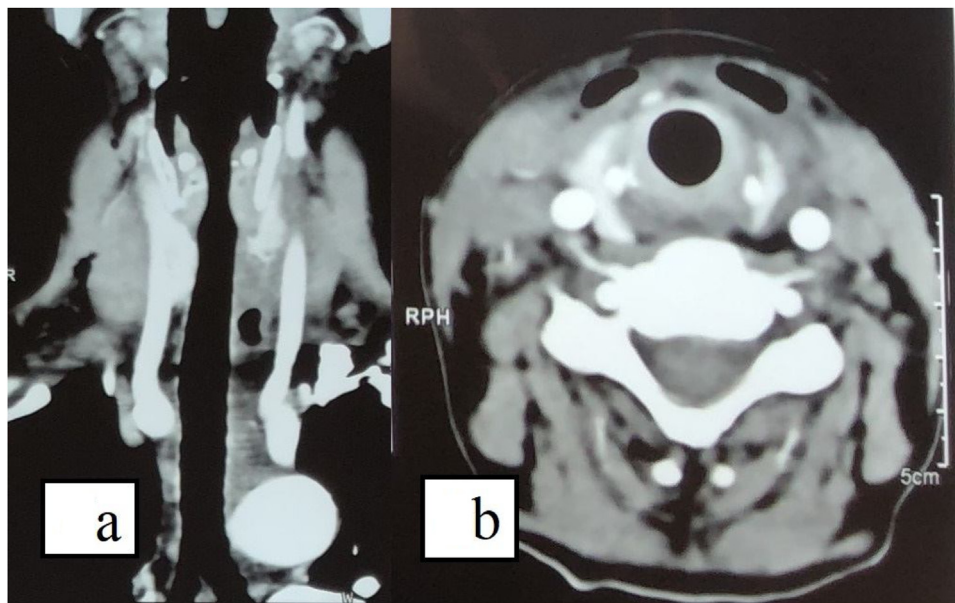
Multi-slice CT scan with angiography: 6a – Frontal scan, 6b – Axial scan.
